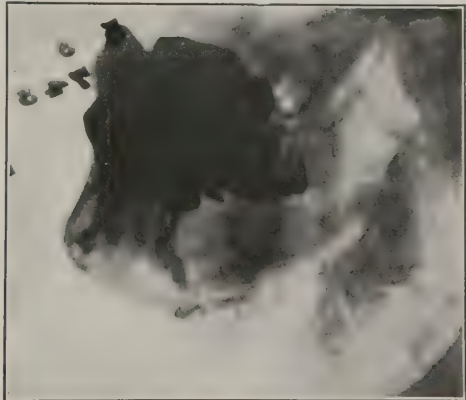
Case 3: Radiograph made one week after operation, showing three osteoperiosteal strips from tibia inserted between fragments.
